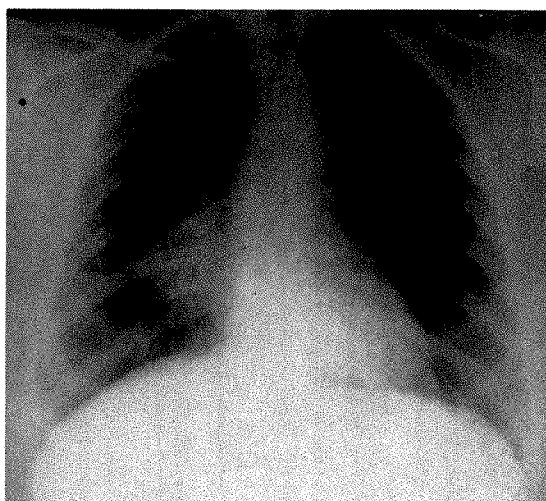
Case III. Right middle lobe hilar mass which was first seen on a survey roentgenogram.
